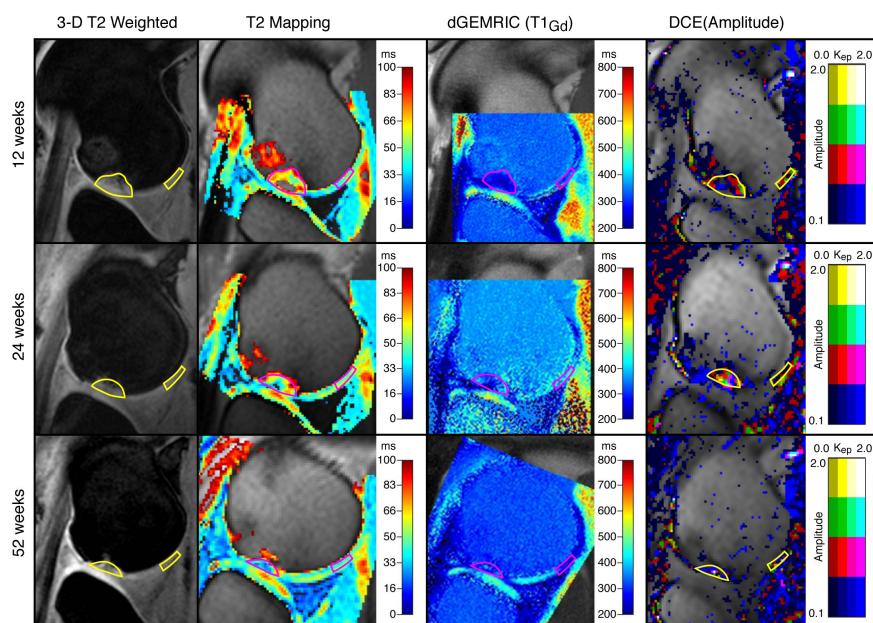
(top left): A. Representative quantitative MRI maps of sagittal sections through the osteochondral defect, showing a lesion treated with Ad-BMP-6 across time using T2 mapping, dGEMRIC and DCE-MRI.
